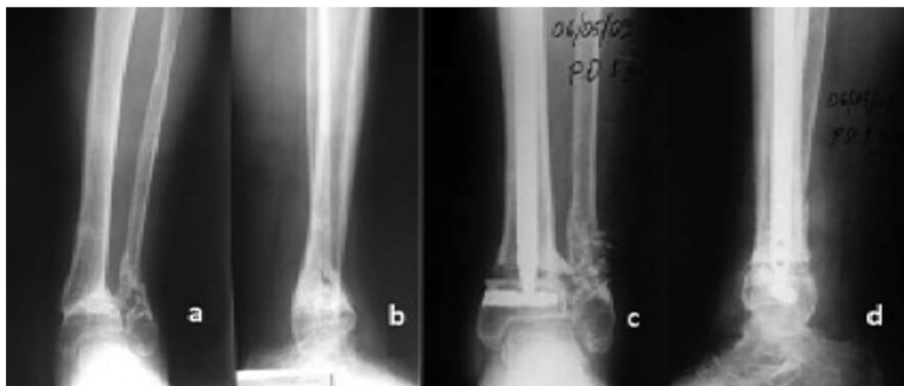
Preoperative AP (a) and lateral (b), and postoperative AP (c) and lateral (d) X-rays of Patient 1.
